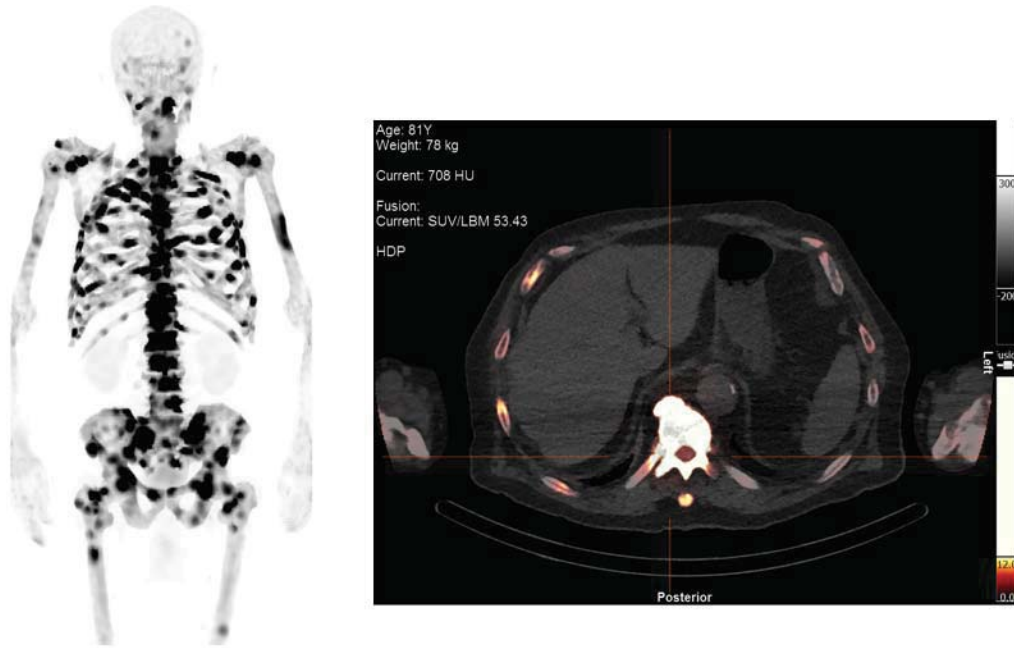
Case 2: SPECT images and SPECT/CT image (metastasis around the spinal canal, the risk of the spinal compression)
